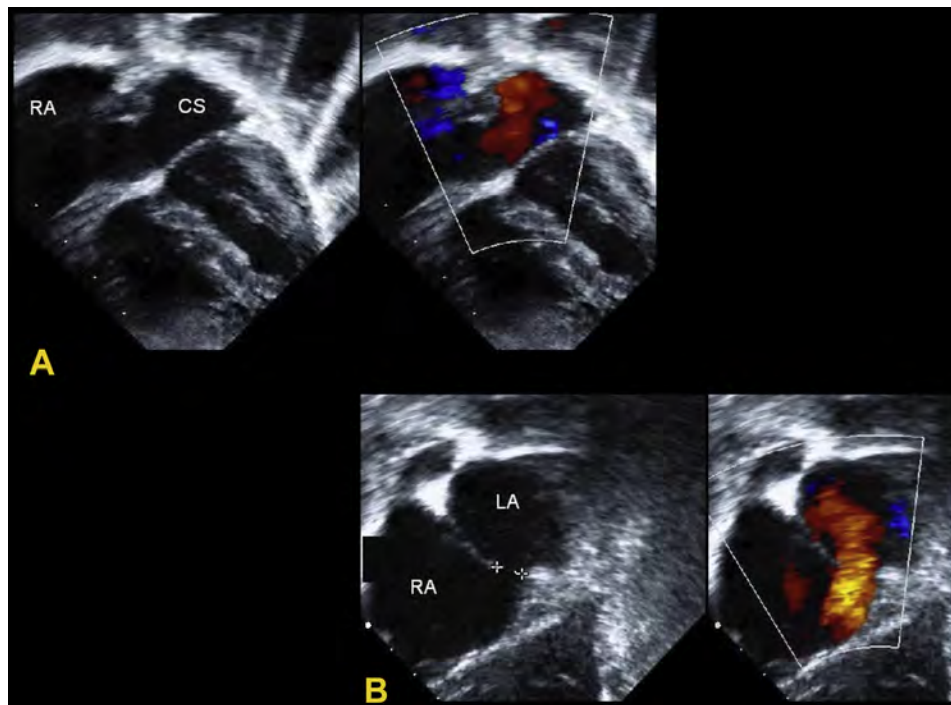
(A) Two-dimensional TTE (*left*) and with color Doppler (*right*) demonstrating unroofed coronary sinus interatrial communication in four-chamber view. Note dilated CS. (B) Two-dimensional TTE (*left*) and with color Doppler (*right*) demonstrating unroofed coronary sinus interatrial communication in subcostal left anterior oblique view. CS, coronary sinus. See also [Videos 11 and 12](#).
